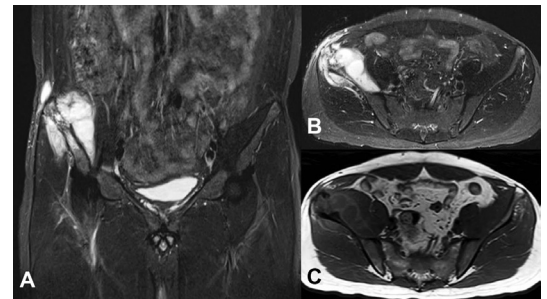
Coronal (A) and axial (B) fat-suppressed MRI shows increased signal intensity in the right iliac bone, small area of liquefaction and adjacent cortical erosion. In continuity with the bone lesion, hyperintense collection is seen medially displacing the iliopsoas muscle and laterally in the gluteal muscles. The collection appears hypointense on axial T1WI (C). T1WI, T1 weighted Image.
